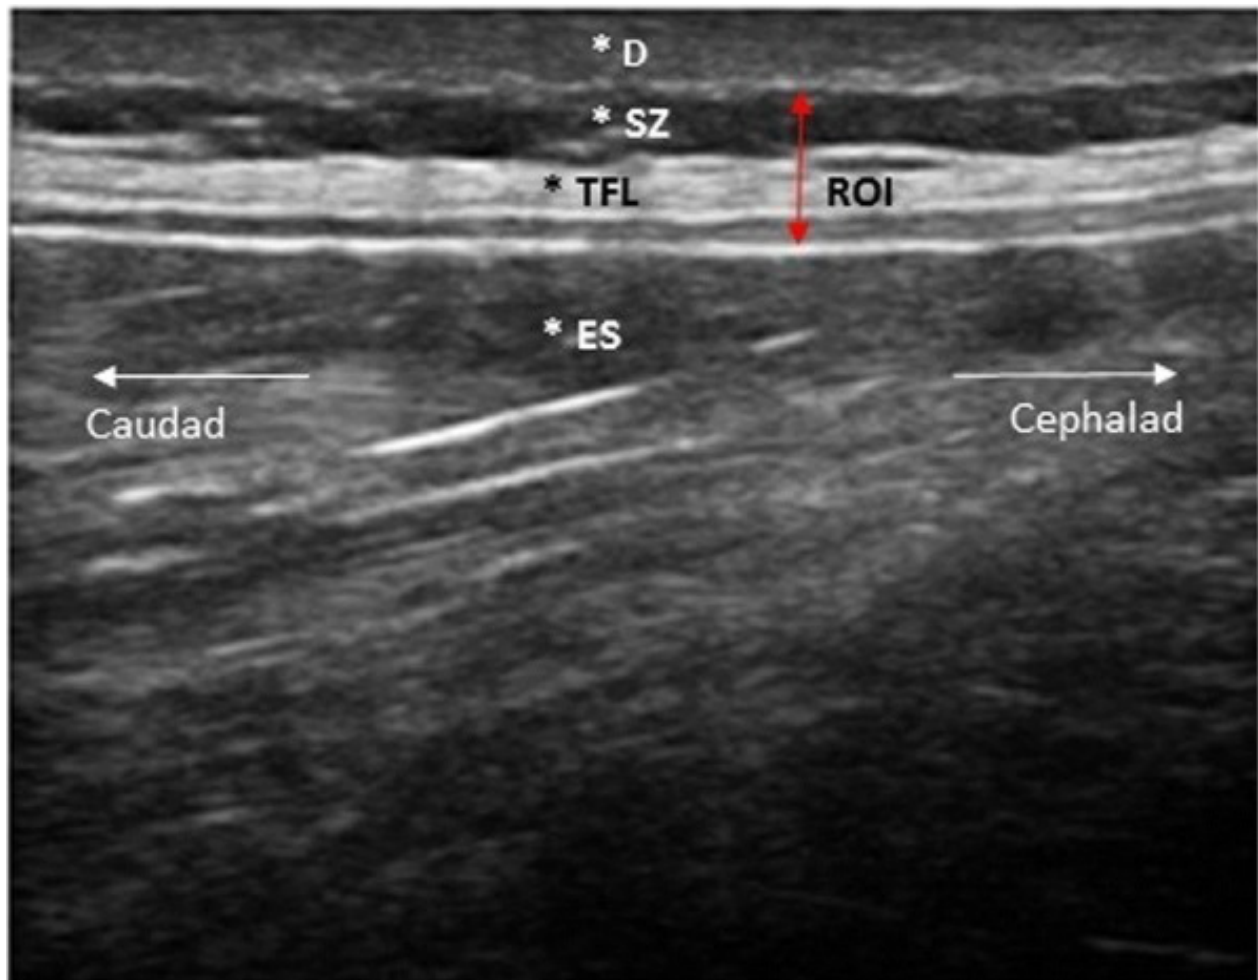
Ultrasound image of the posterior layer of TLF (De Coninck et al., 2018).
